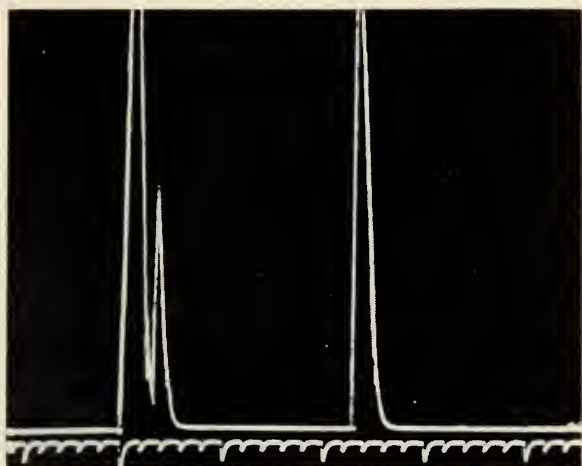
Normal A-mode sonogram of eye. Space without deflections represents corpus vitreous.
